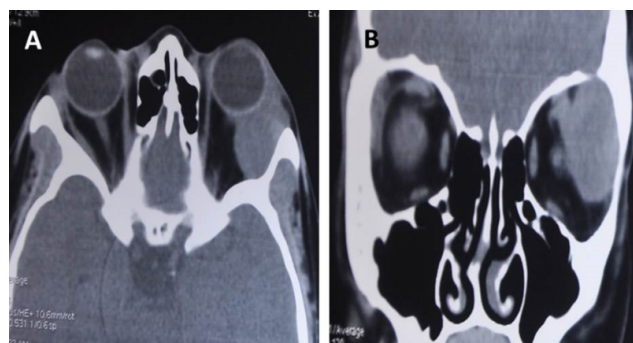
A: Axial CT, B: Coronal CT showing well defined isodense mass lesion in upper quadrant of left orbit with extrinsic compression of superior rectus, lateral rectus muscles with mild pressure erosion of superior wall of orbit.
